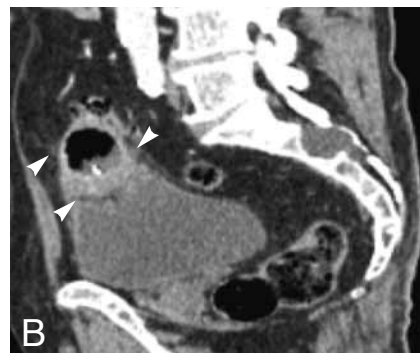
CT-scan of lower abdomen after I.V. contrast material: coronal (A) and sagittal (B) reconstructions, shows sigmoid narrowing (dots), diverticula and along the inferior borders of the sigmoid an elongated mass largely excavated bonding with the vesical dome (between arrowheads).
